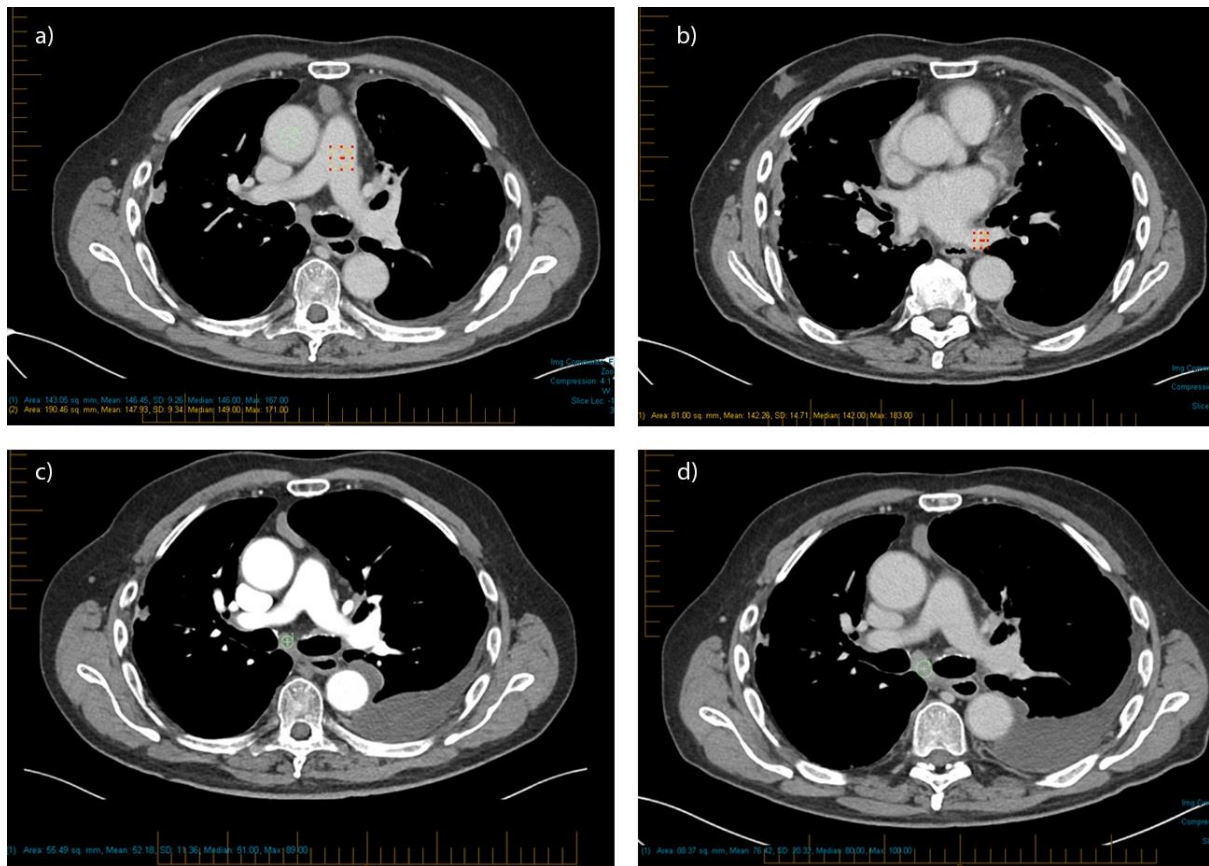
Measurement techniques. Axial venous-phase CT at the level of the pulmonary trunk (a) and pulmonary vein confluence (b). Region of interest (ROI) placement for pulmonary artery, ascending aorta and pulmonary vein. In a different patient, axial arterial-phase (c) and venous-phase (d) CT with ROI placed for attenuation measurement of subcarinal node. Increased attenuation of node on venous phase imaging (HU 76 versus 52). Note is made of a left-sided malignant pleural effusion from pancreatic cancer, where the pleural nodularity is better appreciated in the venous-phase (arrow).
